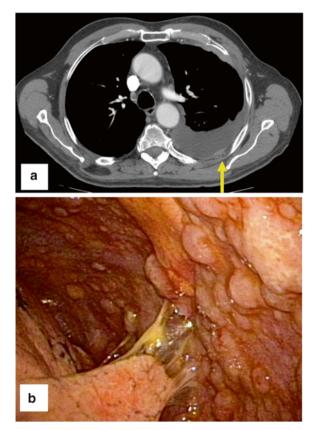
Management of malignant pleural effusions. [Taken from Shannon VR et al. Respiratory complications. Chapter 131 in: *Cancer Medicine*, 8th edition. Hong WK, Bast RC Jr, Hait WN, Kufe DW, Pollock RE, Weichselbaum RR, Holland JF, Frei E III, eds. Shelton, CT: PMPH-USA, LTD. Used with permission from the People's Publishing House-USA.]
